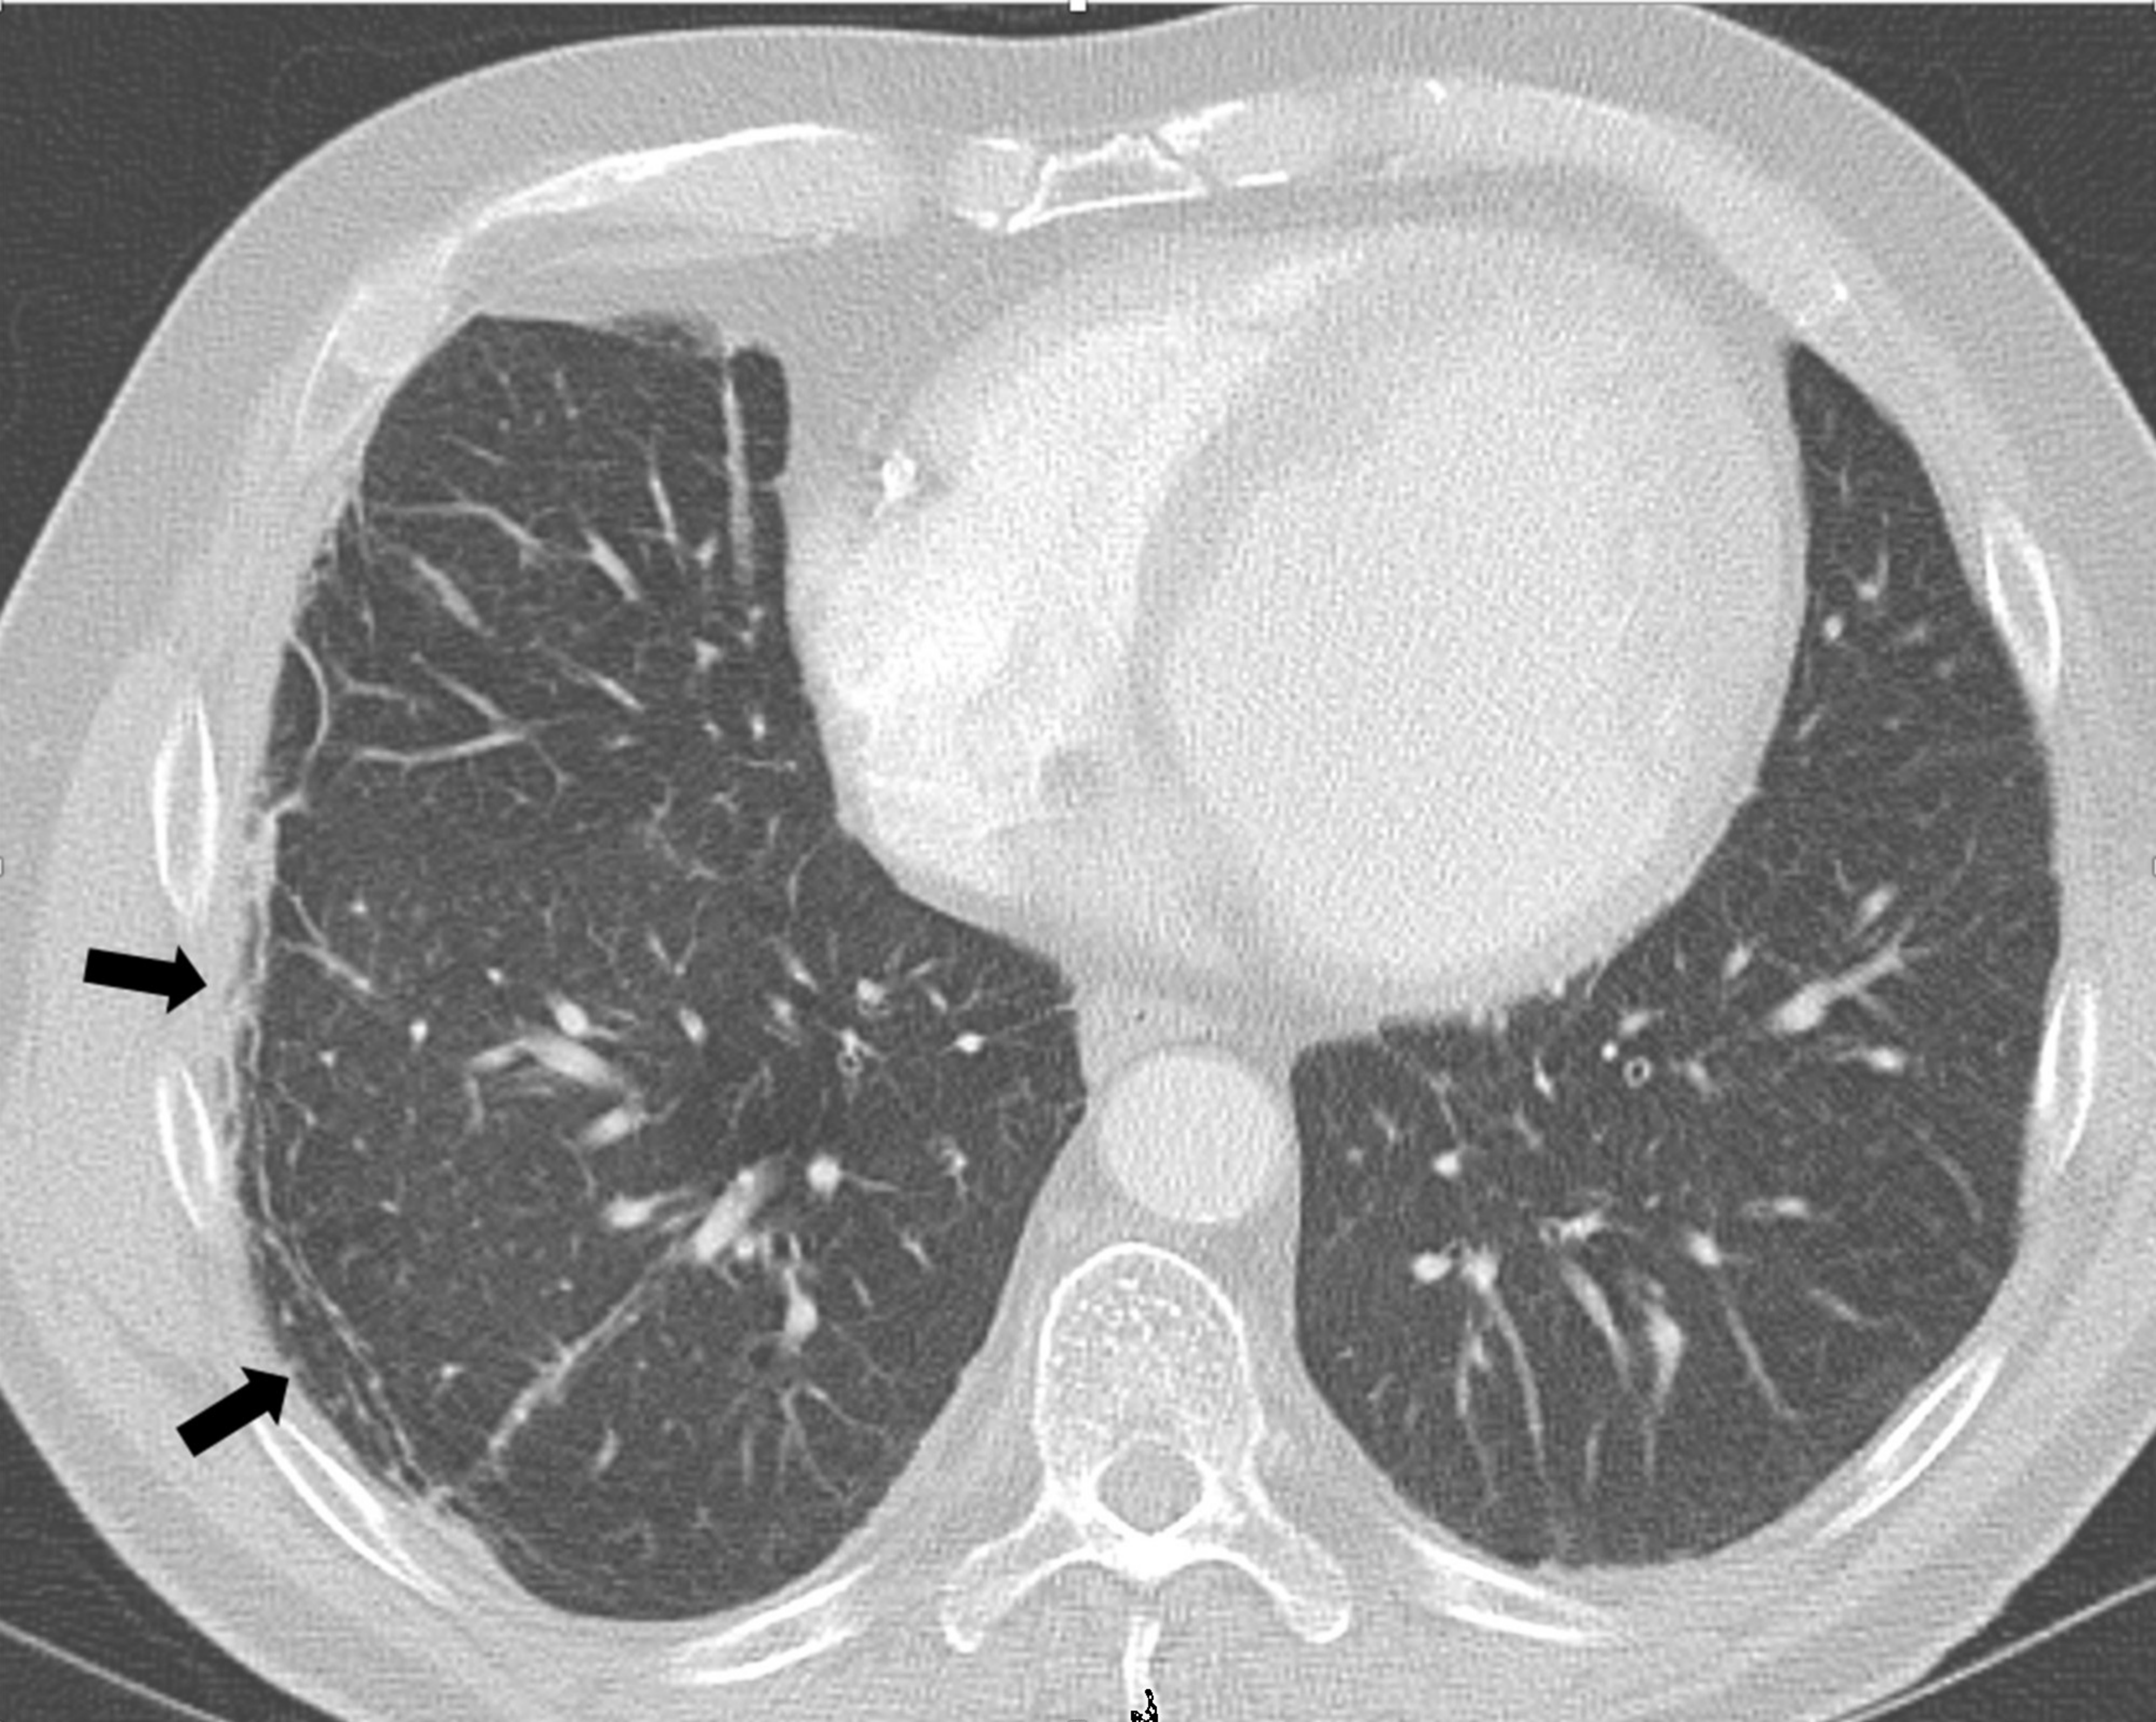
Characteristic HRCT findings of asbestosis including subpleural linear densities; interlobular septal thickening; centrilobular thickening; and subpleural parenchymal bands (Fig. 11, arrow).
